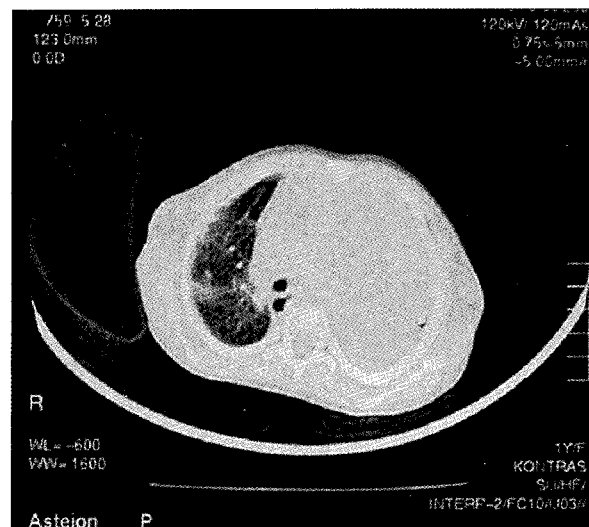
CT scan of the chest showing consolidation of the left lung and prominent hilar lymphadenopathy.
